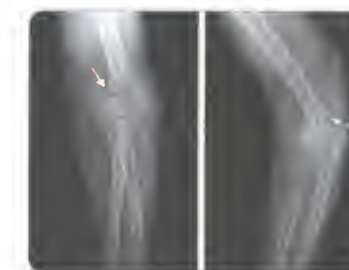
Radiographs showing supracondylar fracture of the shaft of humerus in AP and lateral views (arrows showing)
